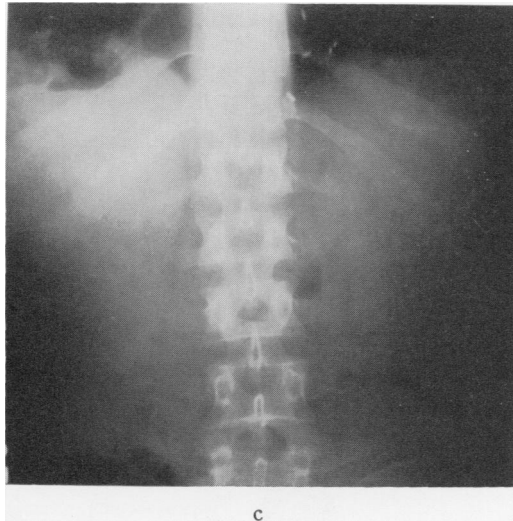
P-A and lateral chest and upright abdominal x-rays, Case 1, after needle aspiration and injection of air into the liver abscess.
